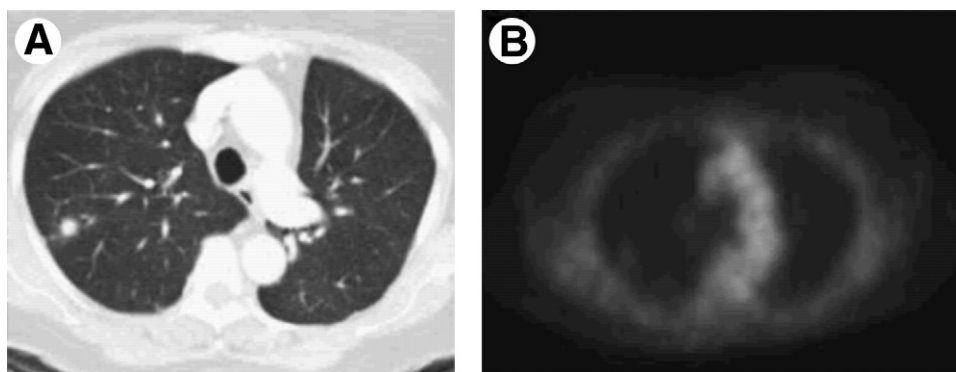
(A) CT and (B) FDG-PET scan of a 69-year-old woman with lung cancer. By use of CT features, the computed likelihood of malignancy was improved (increased) from 0.27 (an indication of a benign nodule, PET alone) to 0.84 (an indication of a malignant nodule, PET + CT).
